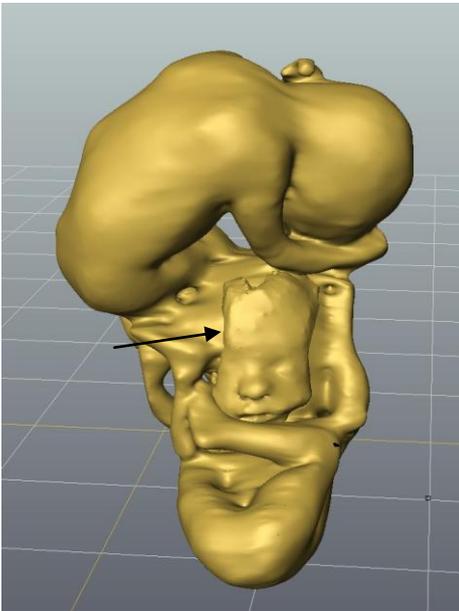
First rough 3D model generated from MRI on Mimics v.12
